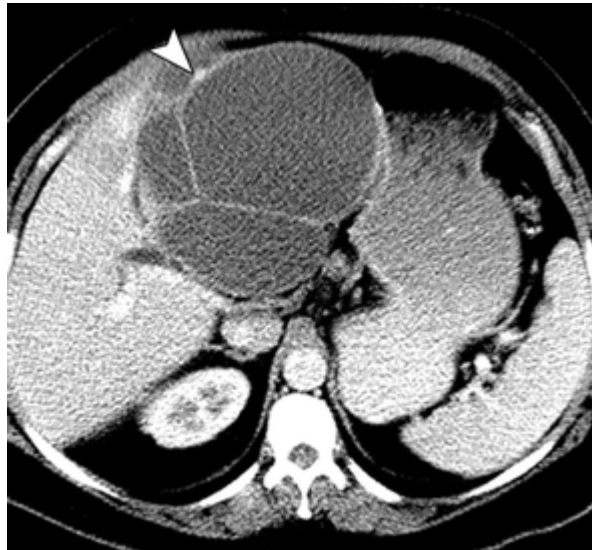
Biliarycystadenoma in 47-year-old woman. Contrast-enhanced CT scan shows multiseptated cystic lesion in left lobe of liver. Note focal papillary excrescence (arrowhead). (Singh et al .(1997).
